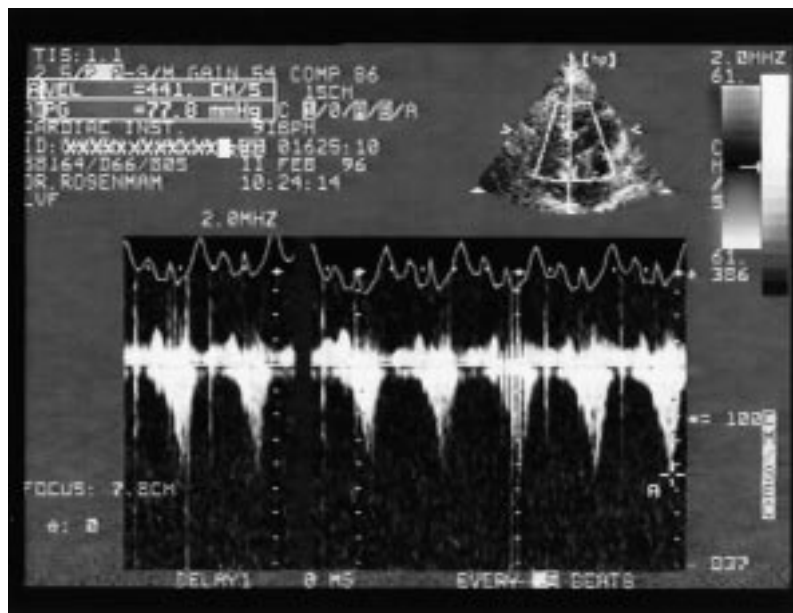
Continuous wave Doppler velocity tracing from the apical four chamber view at the peak of the dobutamine infusion. Note 'late peaking' of the ventricular outflow gradient characteristic of dynamic cavity obstruction.
